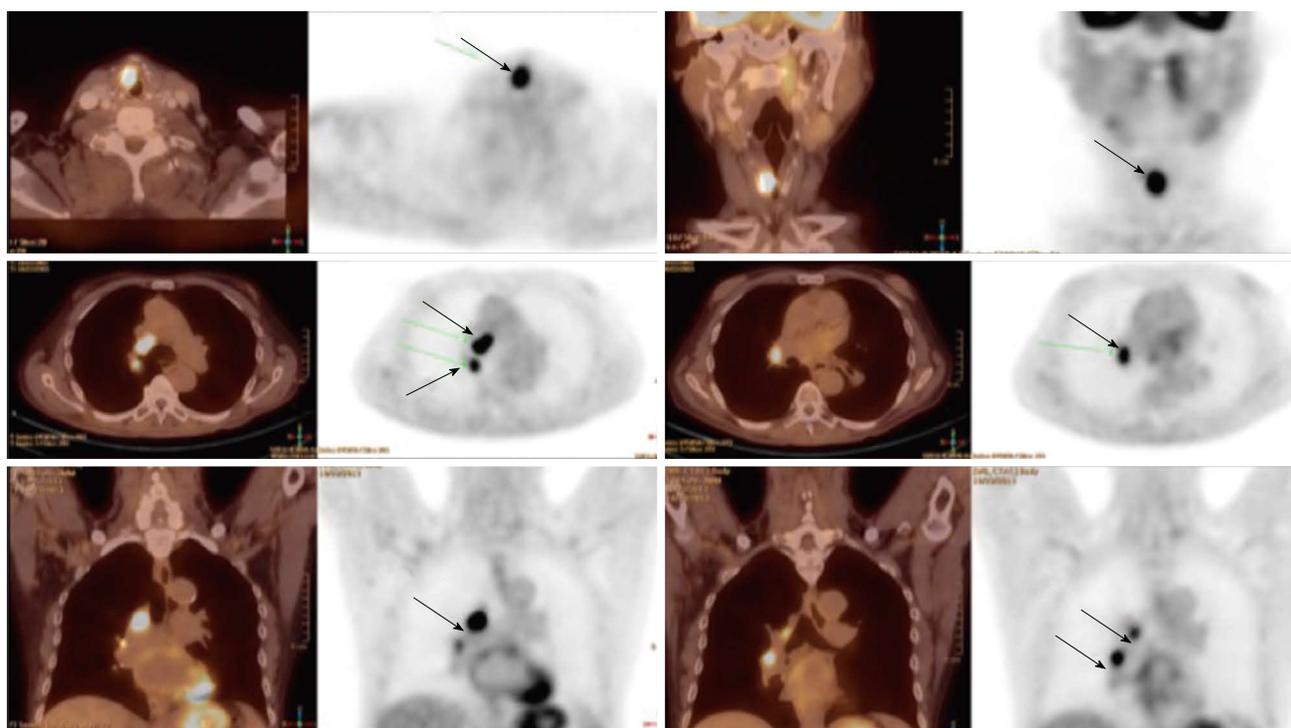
A patient with a synchronous laryngeal and lung squamous cell carcinomas. A 70-year-old male with diagnosis of squamous cell carcinoma of the glottic larynx T3N0M0 (A and B; arrow). He underwent a positron emission tomography/computed tomography scan which revealed additional lesions in the right lung which were biopsied endobronchial and shown to be a second primary lung cancer with mediastinal lymphadenopathy (C and D; arrows).
